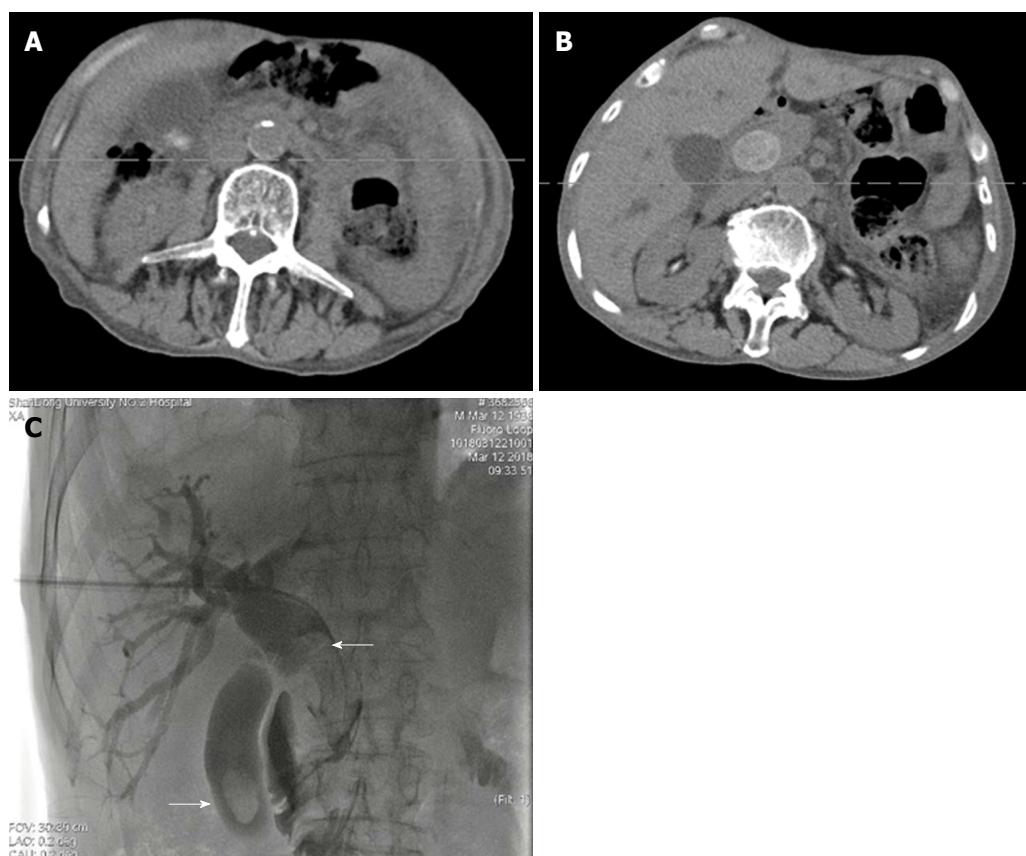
Computed tomography scan and cholangiography showing filling defect in the common bile duct and gallbladder (white arrow). Dilation of the common bile duct and cystic duct was detected. A and B: Ultrasonography, enhanced computed tomography, magnetic resonance cholangiopancreatography, or cholangiography was carried out to determine the diagnosis of stones; C: Advancing cholangiography was performed to detect the number, size, and location of stones.
